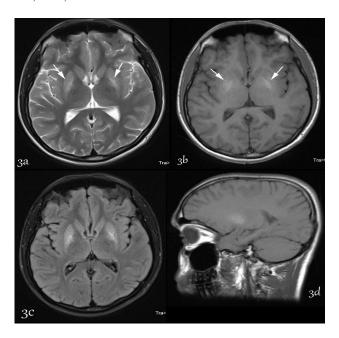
Initial MRI of brain in Index patient showing symmetrical increased signal intensity in basal ganglia (globus pallidus) region in T2 and flair.
